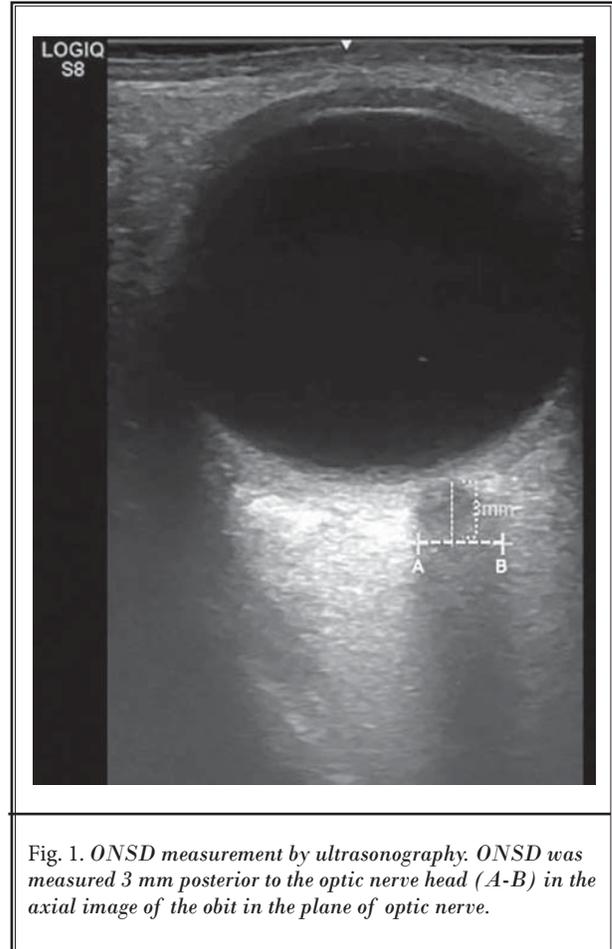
ONSD measurement by ultrasonography. ONSD was measured 3 mm posterior to the optic nerve head (A-B) in the axial image of the orbit in the plane of optic nerve.
